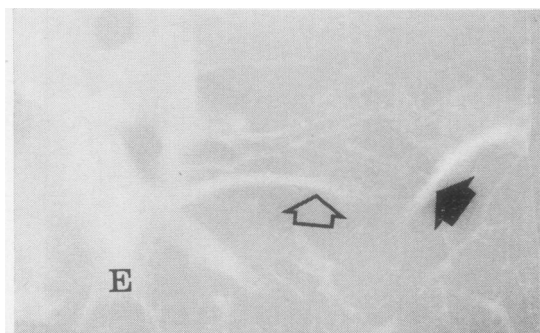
(E) Radiograph of thin lung slice showing pulmonary artery branch ending in curved line shadow.
